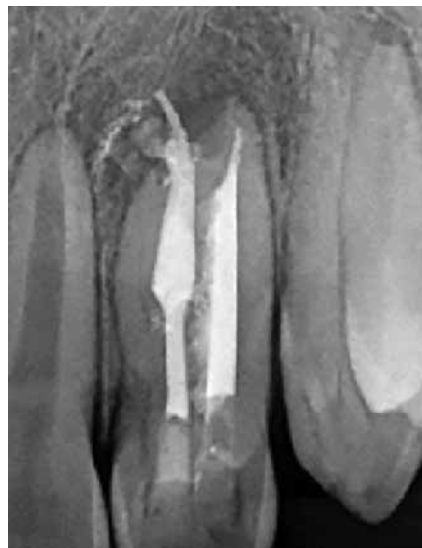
Periapical control radiograph at 18 months.
